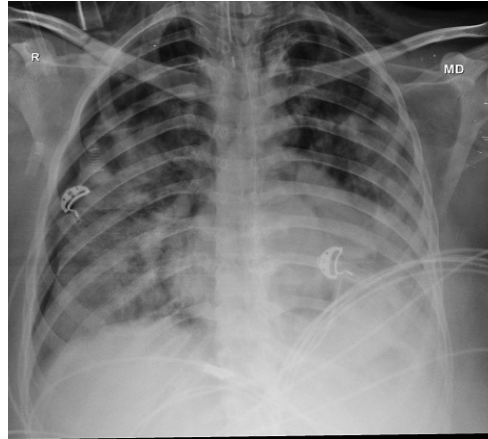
X-ray chest done on Day 3 showing a right-sided pneumothorax.
